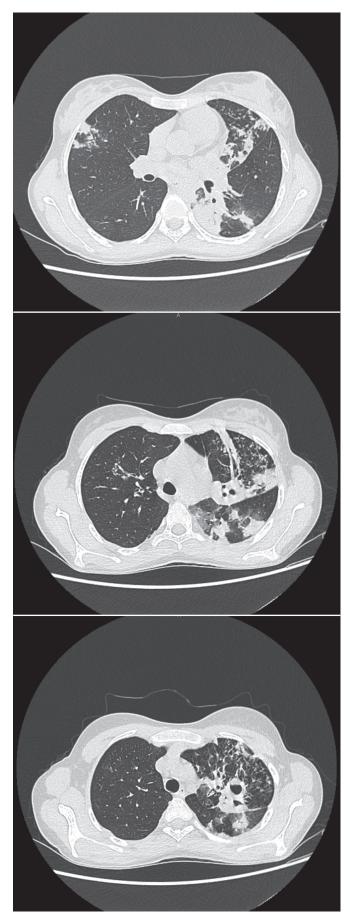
Chest CT before treatment onset. Images taken at different chest levels
